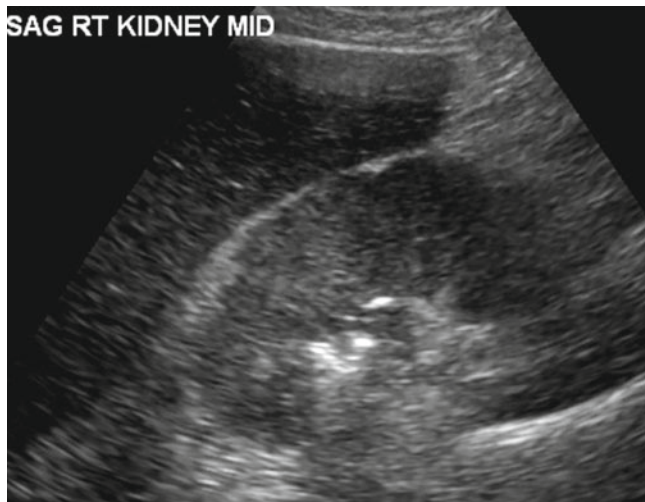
Emphysematous pyelonephritis. Ultrasound image of the right kidney shows echogenic foci with dirty shadowing within the right kidney, consistent with gas
